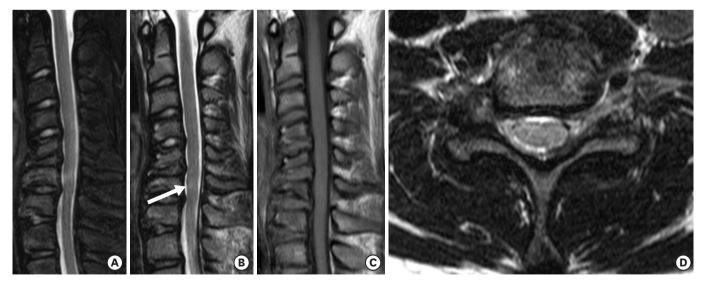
(A) Sagittal T2-WI with fat saturation, (B) T2-WI, (C) T1-WI, and (D) axial T2-WI of magnetic resonance imaging. (A-C) Small bone fragments with T2 iso- to high signal, and T1 low signal change are shown in C4 to C7 vertebral bodies, suggesting acute to subacute stage of fractures. (B, D) Subtle high signal change (white arrow) in the spinal cord of C6 body level, possibly early stage of myelopathy. However, this finding is not definite on axial image on that level. WI: weighted image.
